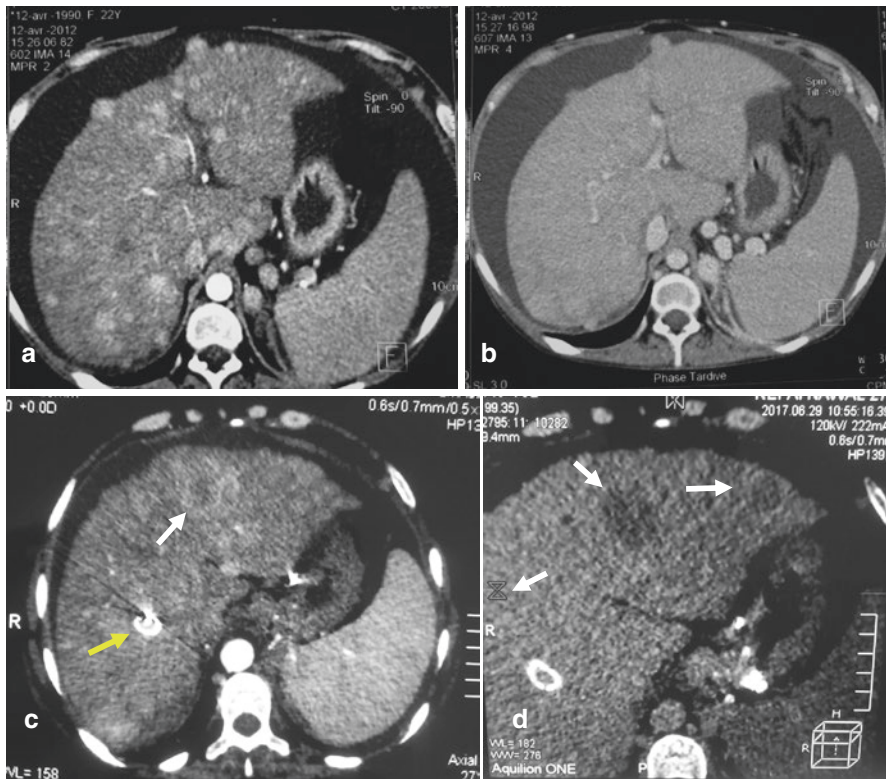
A young 23-year-old patient with BCS (hepatic vein thrombosis): (a) Contrast-enhanced CT scan showing multiple, small, hypervascular benign lesions; (b) Without washout in portal and delayed phase. Five years later, 11 years after BCS diagnosis, an increase in the AFP level led to the diagnosis of multiple HCCs; (c) Enhanced CT scan showing in segment II a 3 cm hypervascular nodule, heterogeneously enhanced on arterial phase, with central necrosis (white arrow) in a cirrhotic liver with irregular margins. Transjugular intrahepatic shunt (TIPS) (yellow arrow); (d) Multiple lesions of the left lobe showing a complete washout on the delayed phase; (e) Chemoembolization after selective catheterism of the right hepatic artery; (f) Multiple blush after injection (arrows) corresponding to multiple HCCs (with courtesy of Pr SA. Faraoun and Dr A. Habouchi)
